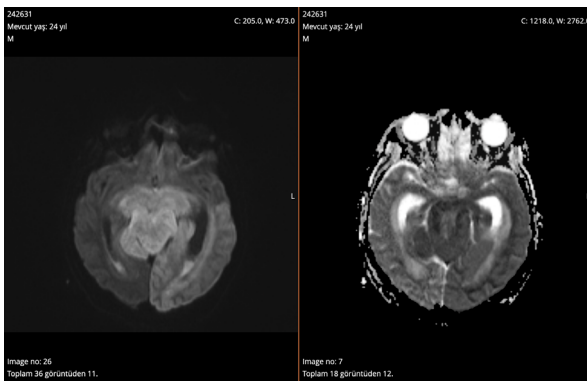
Contrast-enhanced brain MRI demonstrating fluid-debris levels within the occipital horns of the lateral ventricles and restricted diffusion, consistent with pyogenic ventriculitis.
